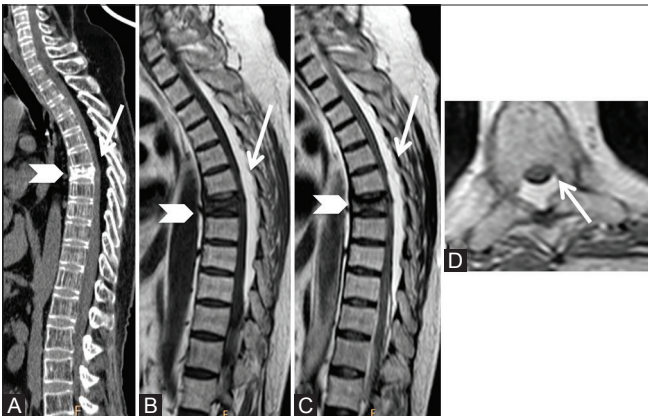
(A-D): Benign lesions: Spinal Epidural lipomatosis: 48-year-old male on long-term steroids. Sagittal computed tomography scan (A), T1-weighted (B), T2-weighted (C), and axial T2-weighted (D) images showing excessive proliferation of posterior epidural fat (arrow) in thoracic region. Note the prominence of trabeculae and fatty marrow in vertebrae suggestive of osteoporosis. Old compression fracture of T6 vertebral body (arrowhead) is also seen
